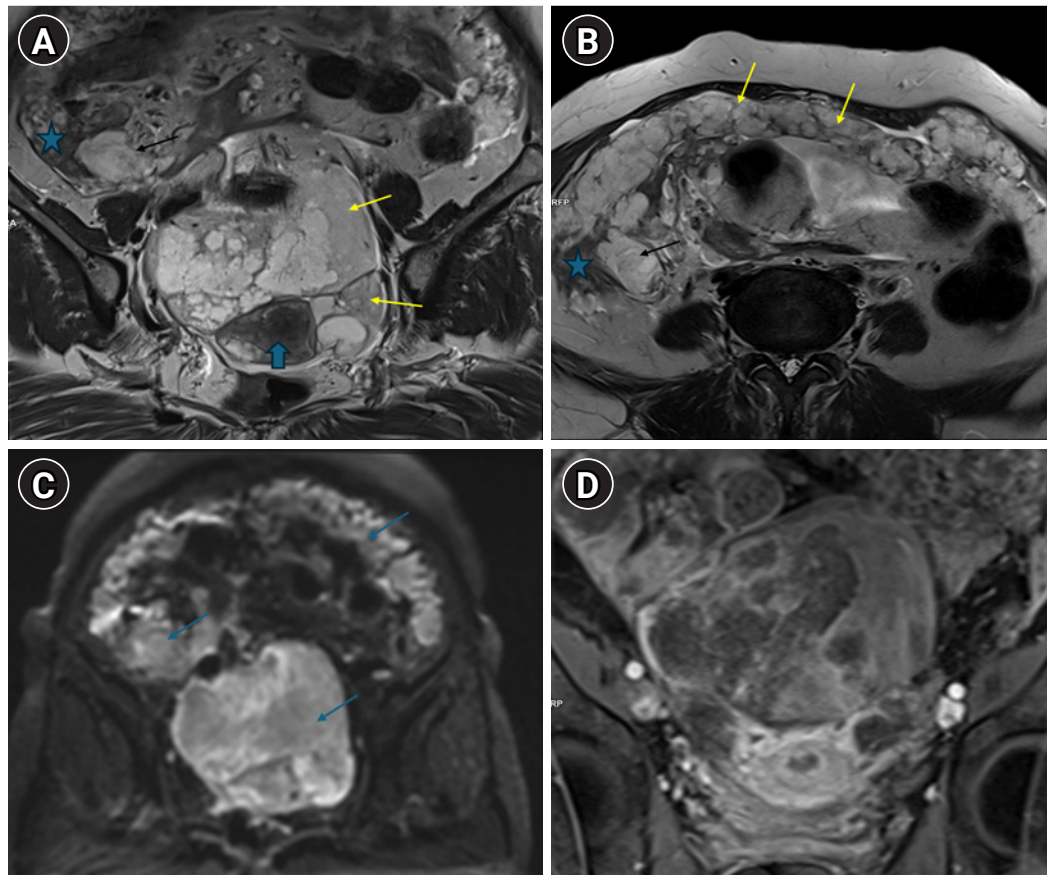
Magnetic resonance imaging findings. (A) Coronal T2-weighted image showing bilateral T2-hyperintense ovarian mass lesions (yellow arrows). The mass (black arrow) infiltrates the cecum (blue asterisk). The appendix is not separately visualized. The blue block arrow indicates the uterus. (B) Axial T2-weighted image showing a tumor deposit (black arrow) infiltrating the cecum (blue asterisk), with omental deposits resulting in caking (yellow arrows). (C) Axial diffusion-weighted image at a high b-value of 1,000 s/mm² showing restricted diffusion in the omentum, ovarian mass lesions, and cecal deposit. (D) Coronal contrast-enhanced T1-weighted fat-saturated image showing heterogeneous enhancement of the ovarian mass.
